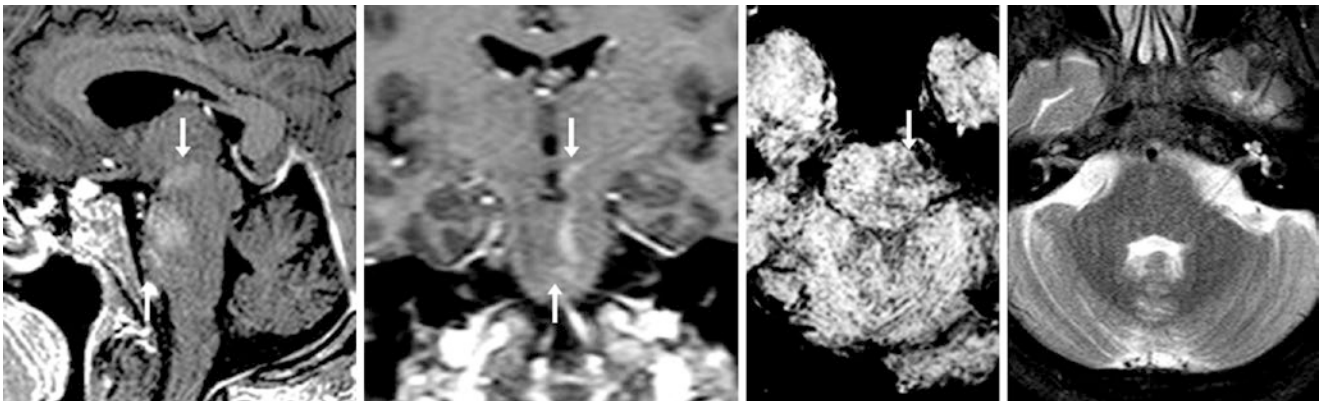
A 37 year old with altered mentation who had had either a diffuse, multilevel BCT or three separate BCTs at the level of the mid-brain, mid-pons, and lower pons (arrows) on a 1.5T MRI with post-contrast sagittal (*left*) and coronal (*left middle*) GE T1WIs. On an SWI that was mildly compromised because of motion (*right middle*), the BCT had mild hypointensity. The T2WI (*right*) appeared normal
